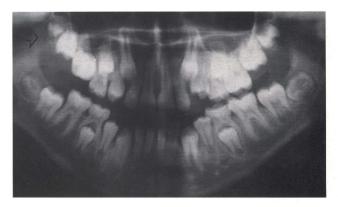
Preoperative panoral radiograph showing radiopacity in the area of the maxillary right first permanent molar and dens invaginatus in both maxillary lateral incisors.
